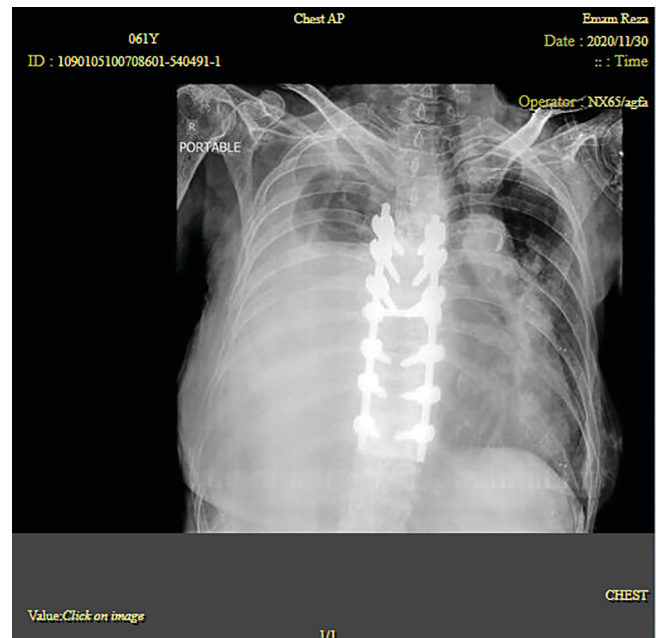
Chest X-ray, right massive pleural effusion.
